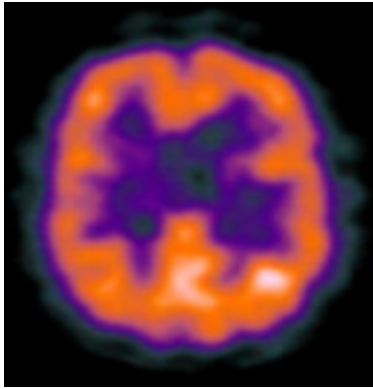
Transverse SPECT image of the Brain.
